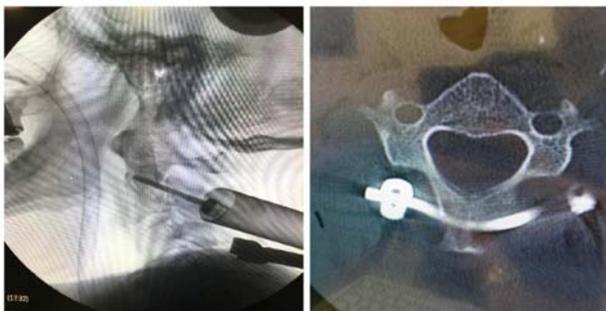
Left image demonstrates intraoperative image intensifier visualisation of pars interarticularis aka 'pedicle' screw insertion. Right image demonstrates post-op CT of rod-screw construct *in situ*.
